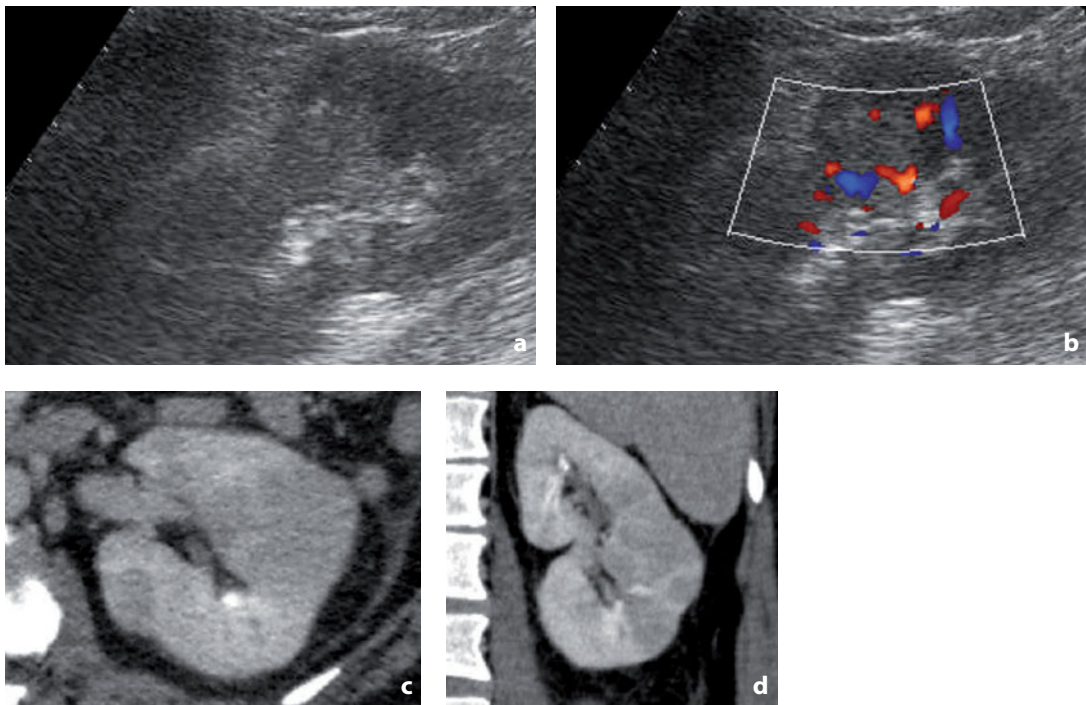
Ultrasonography and contrast-enhanced CT. Acute focal pyelonephritis. a The US study shows ill-defined hypoechoic swelling with reduced perfusion at color Doppler (b). The contrast-enhanced CT study in the axial (c) and coronal (d) planes confirms the hypoattenuating lesion with ill-defined margins, which produces a bulge in the renal profile
